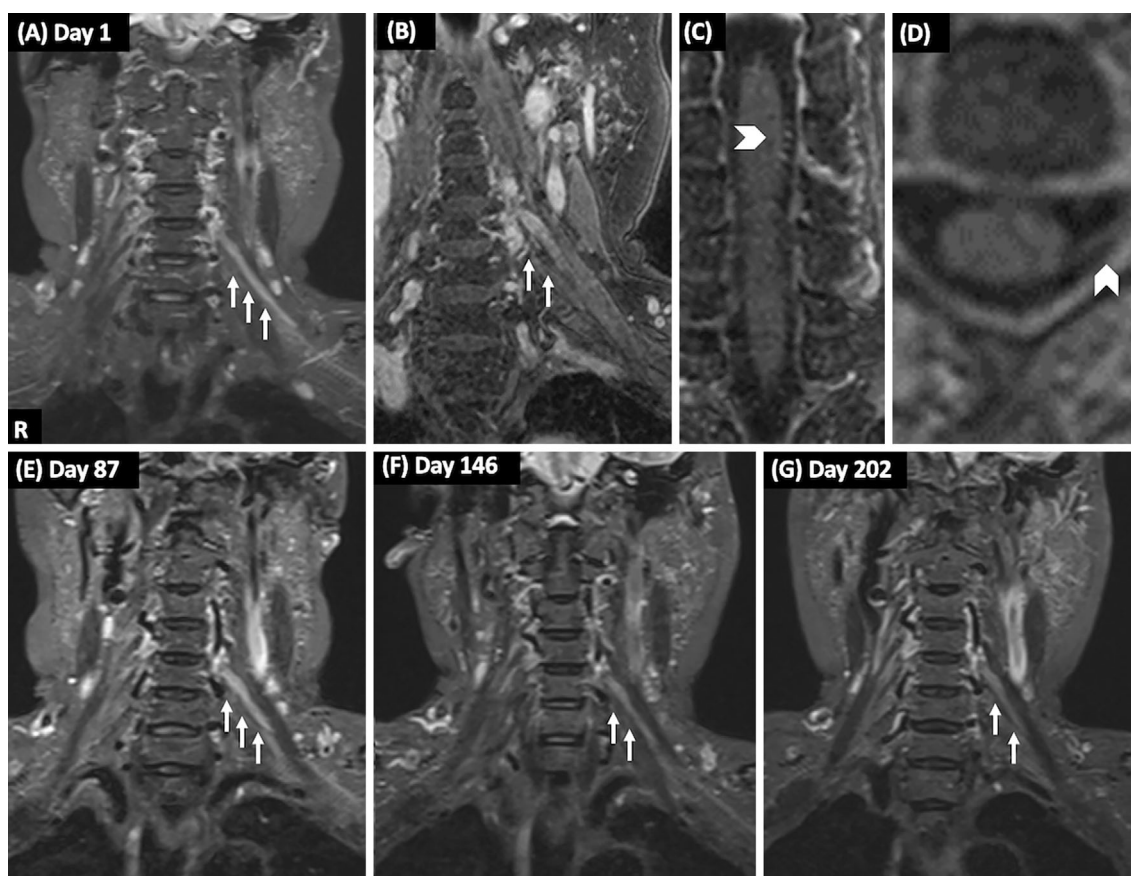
MRI findings. (A) Enlargement and high-intensity signal in the left C5 nerve root (arrows) are detected on spinal short inversion time inversion recovery (STIR)-MRI. (B-D) Contrast spinal MRI shows enhancement in the left C5 nerve root (arrows) including the dorsal root (arrowheads) [(B, C) coronal view, (D) axial view]. (E-G) Enlargement and high-intensity signal are gradually decreased on STIR-MRI. R: right
